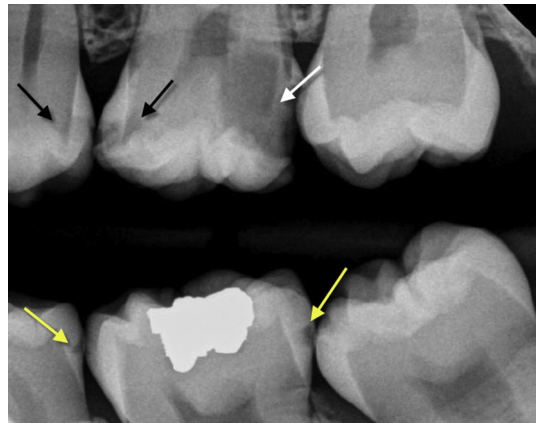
Bitewing intraoral radiograph shows examples of carious lesions. The yellow arrows indicate incipient lesions that are limited to the enamel. The black arrows indicate caries into the DEJ and the white arrow indicates severe caries that has reached the pulp.
